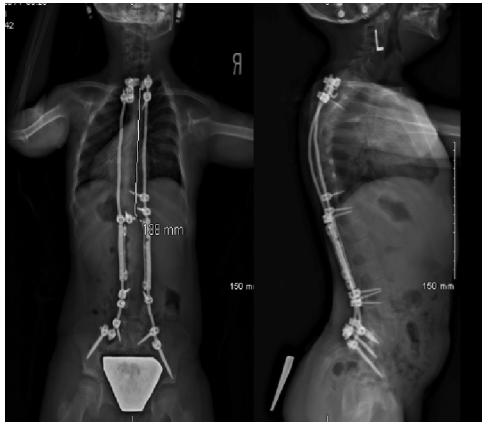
Final x-rays of the patient at the age of 8 years and 8 months showing a stable construct and the rod-to-rod connector on the left side.
